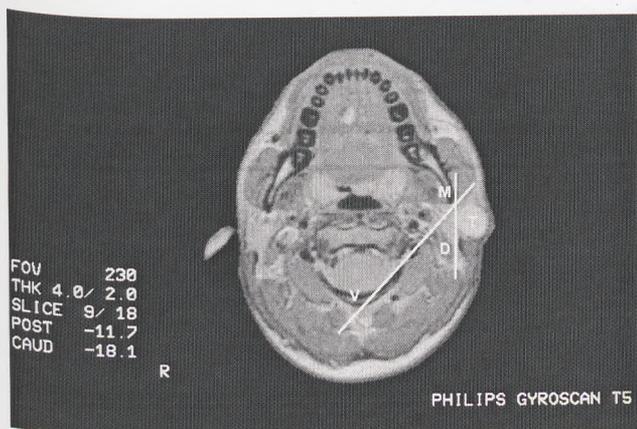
Axial Magnetic Resonance Image of a parotid gland tumour. Both the FN line and the U line are drawn on the scan. The tumour was designated as a superficial lobe tumour since it is located lateral to both lines. At surgery, the tumour was found to be located superficial to the facial nerve. V = vertebra, D = digastric muscle, M = mandible, T = tumour, arrow points to the retromandibular vein.
